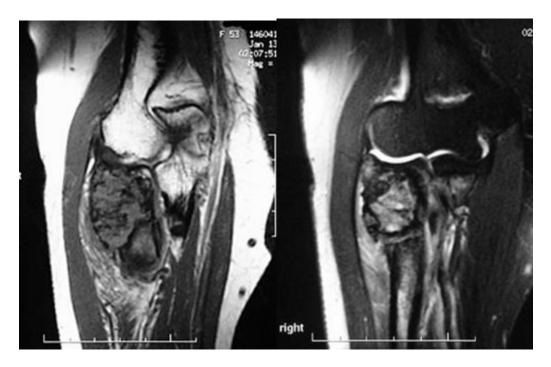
MR imaging: Coronal T1
